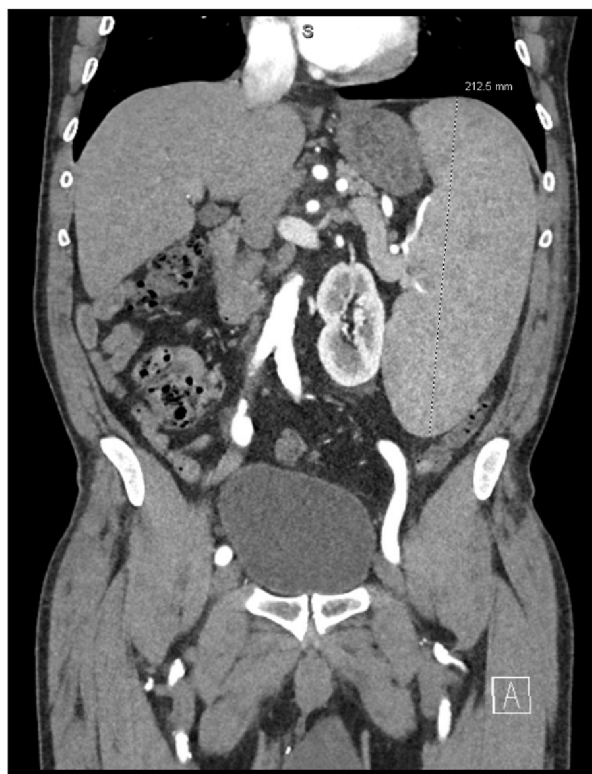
Computed tomography (CT) of the abdomen and pelvis demonstrating marked splenomegaly measuring approximately 21.2 cm in craniocaudal length with associated mass effect on adjacent structures.
